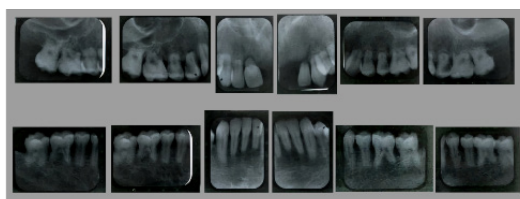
Full mouth periapical radiographs showing apical root resorption.
